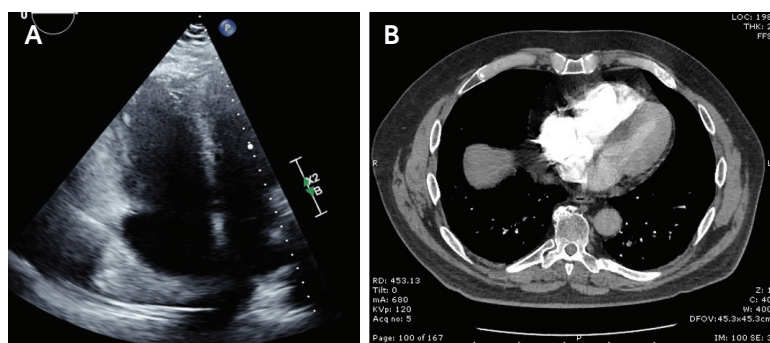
Echocardiogram (A) and CT (B) demonstrating an enlarged right ventricle.
